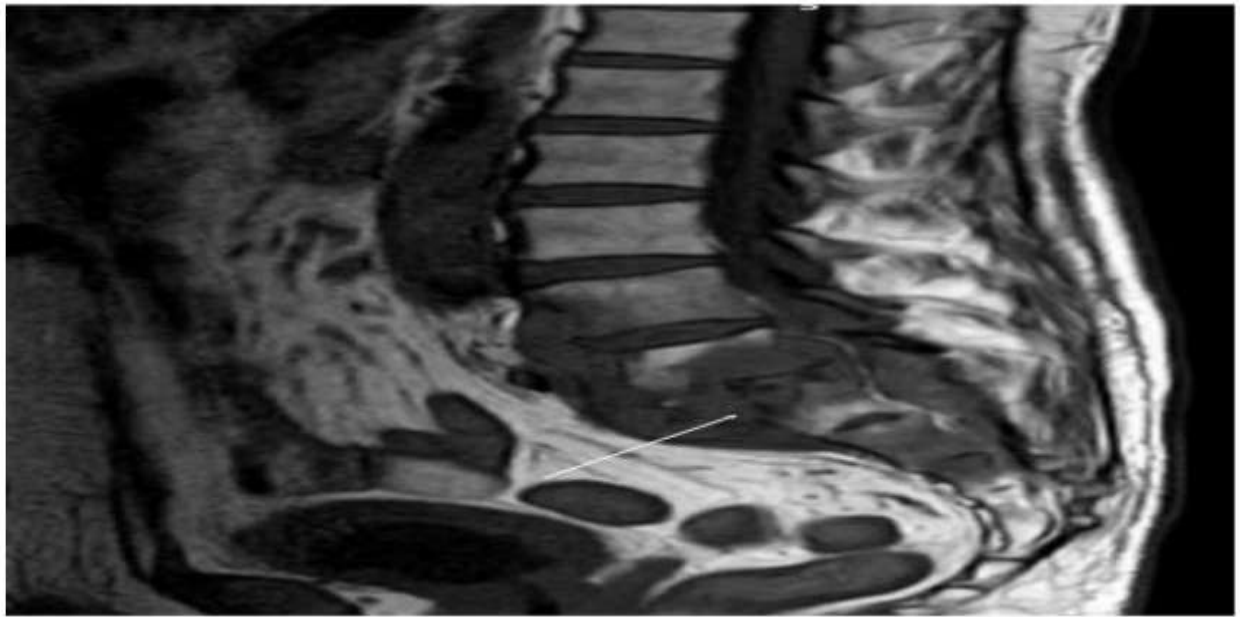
MRI spine with features of Pott's disease
